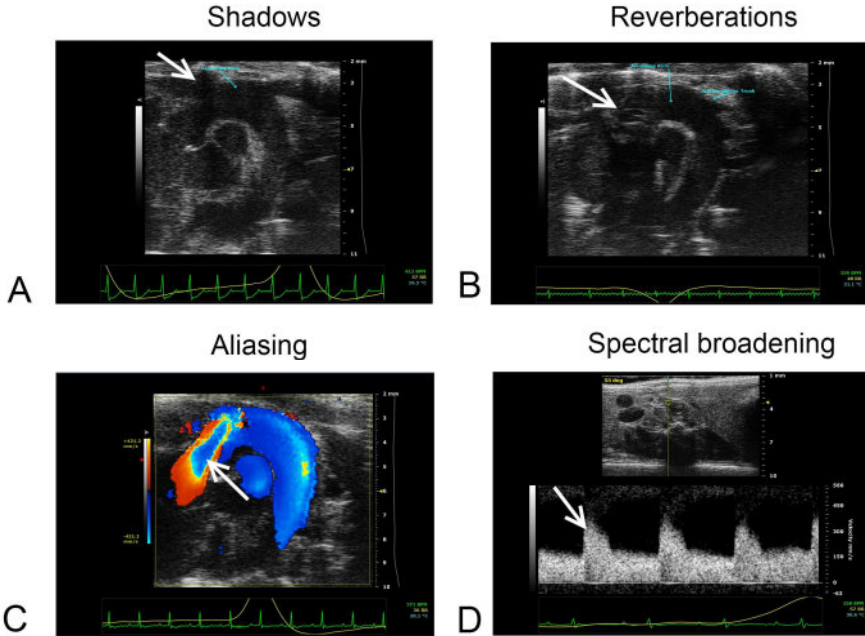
Different image artifacts in ultrasound images obtained within the context of chapter 9. All artifacts are indicated with a white arrow. A. Shadows: a shadow (probably cast by a rib) is present in the ascending part of the aortic arch. B. Reverberations: an artificial stationary structure is present in the ascending part of the aortic arch. C. Aliasing: artificial blue velocities (directed towards the heart) are detected in the central part of the ascending aorta due to a PRF (Pulse Repetition Frequency) that is set too low. D. Spectral broadening: differences in detected velocities of the scatterers within the sample volume can cause a broad, not clearly delineated velocity profile.
